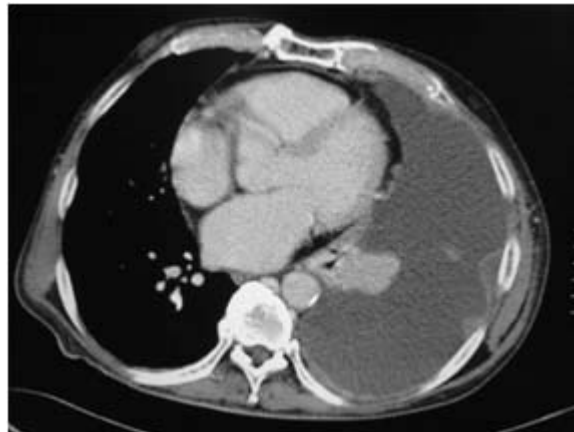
A 59-year-old man with colon cancer, contrast-enhanced chest CT of shows diffuse nodular pleural thickening.
